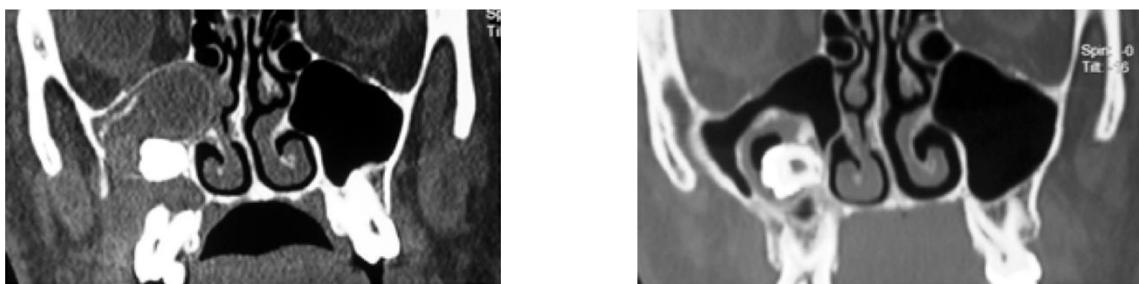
Coronal CT scans of KCOT of right maxilla, before and six months after the decompression. Significant reduction in size of the lesion is apparent. [19]
